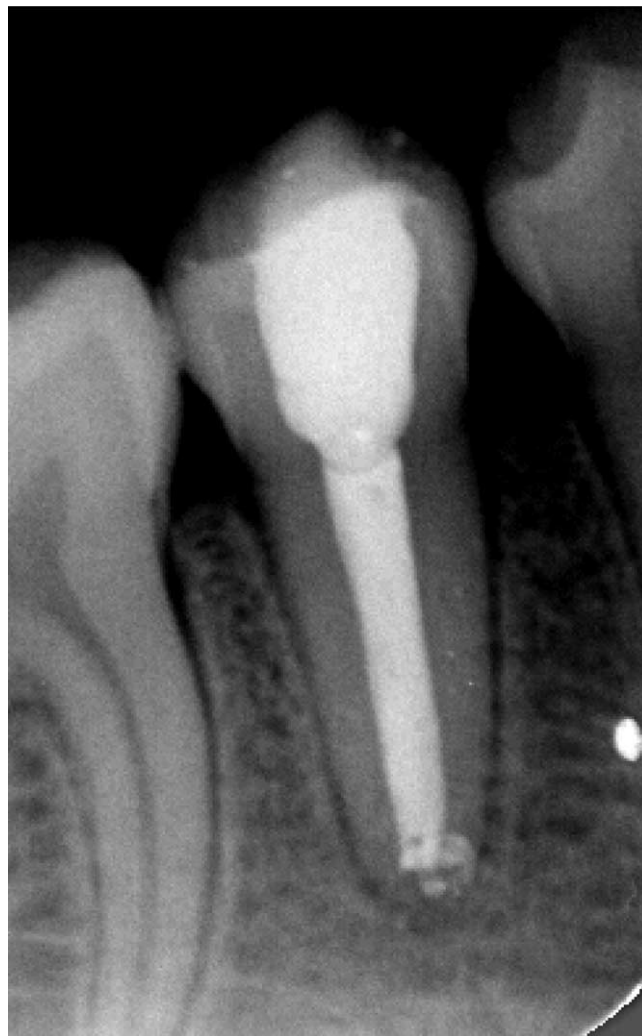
Teeth #28 and #29. Pretreatment radiograph (September 9, 2003).
